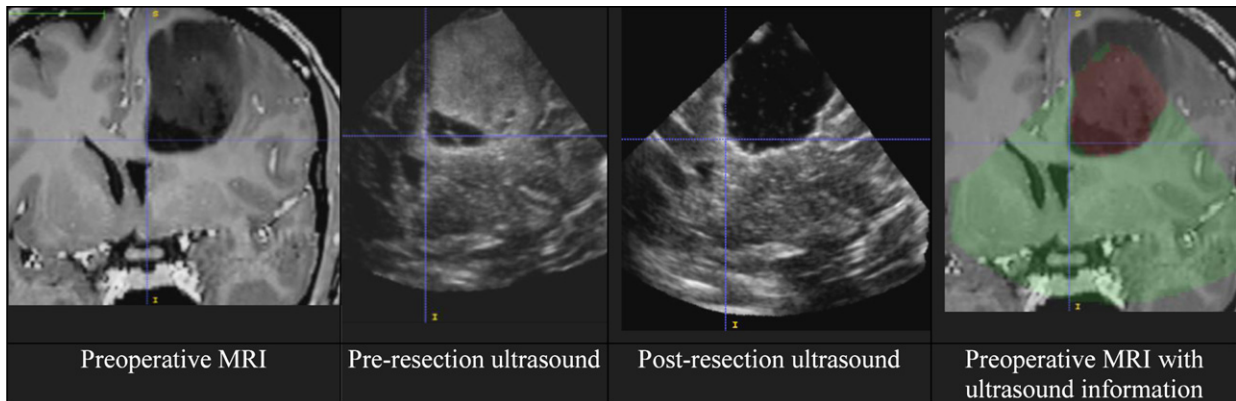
Images that could be presented to the surgeon at the end of resection. From left to right: preoperative MR image; rigidly registered preresection ultrasound; rigidly registered postresection ultrasound; preoperative MR image with overlaid nonlinearly warped resection cavity (red); and the region covered by the postresection ultrasound (green).
